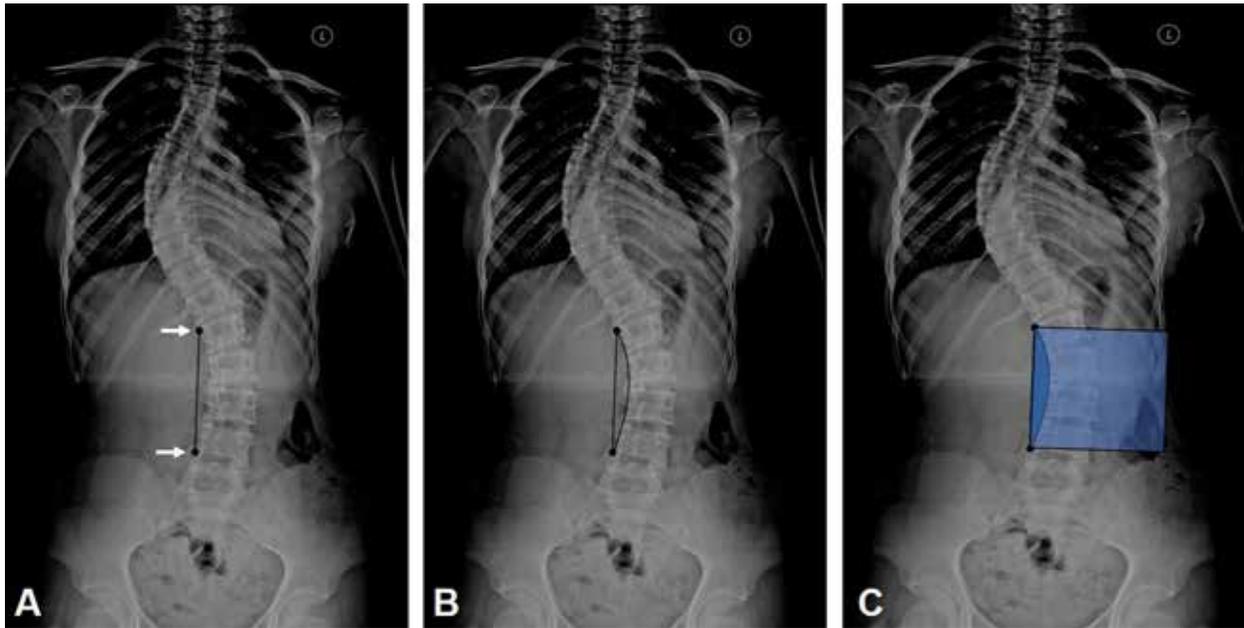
(A) White arrows show the superomedial and inferomedial corners of the vertebral bodies of the superior and inferior end vertebrae; (B) Anteroposterior X-ray images showing the semilunar area drawn for the estimation of the projection area per length squared; (C) The PAL of the curvature expresses the surface area proportion of the semilunar area within the projection area of the square, which is the virtual reference surface area obtained from the square of the length.
